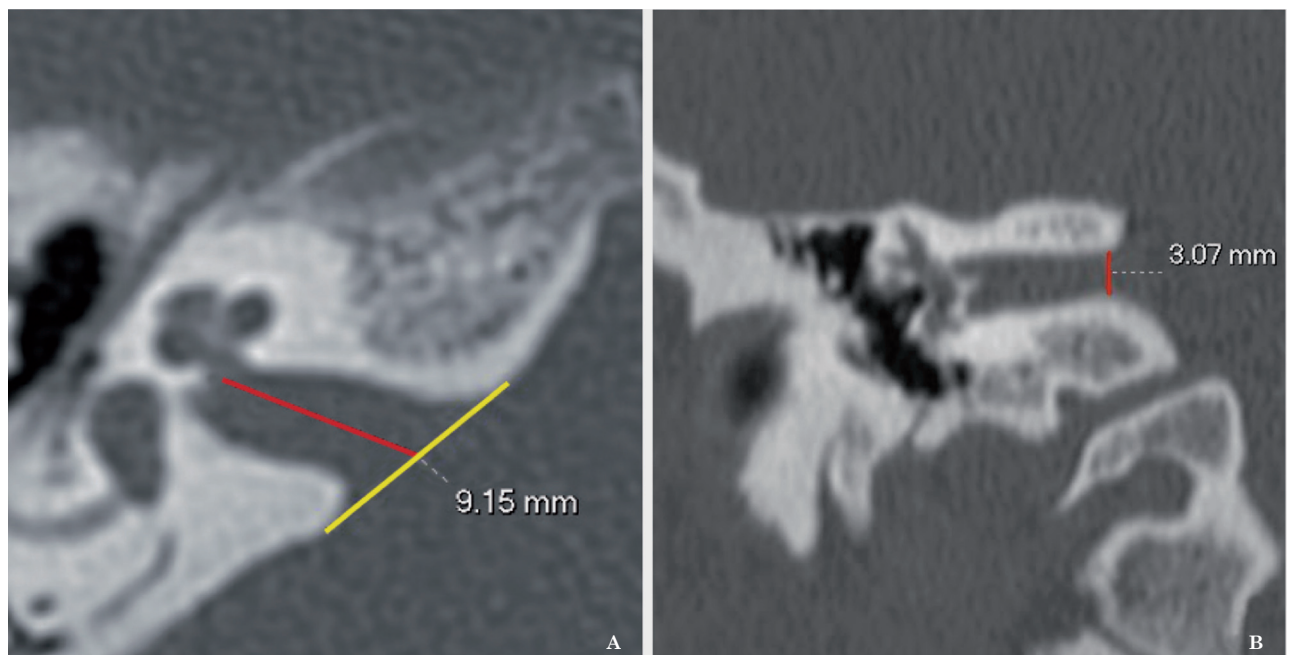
Axial and coronal CT images: length of the internal auditory canal (A) and diameter of the internal acoustic meatus (B).
